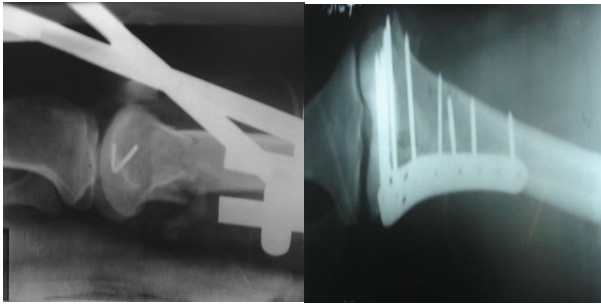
(c & d): X-rays after limited condylar fixation and spanning ex fix application.
